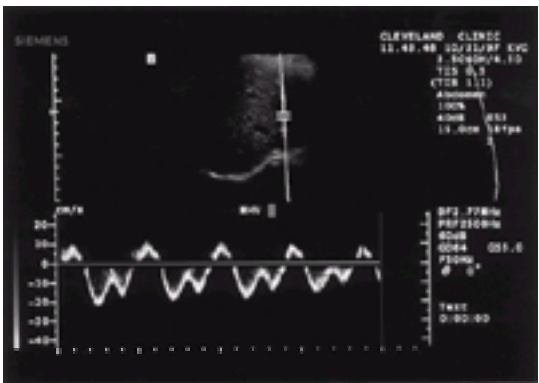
Doppler ultrasound of hepatic veins. The patent hepatic vein can be seen and the tracing shows normal phasic flow pattern. If these two components are absent, the diagnosis of Budd–Chiari syndrome must be entertained.
